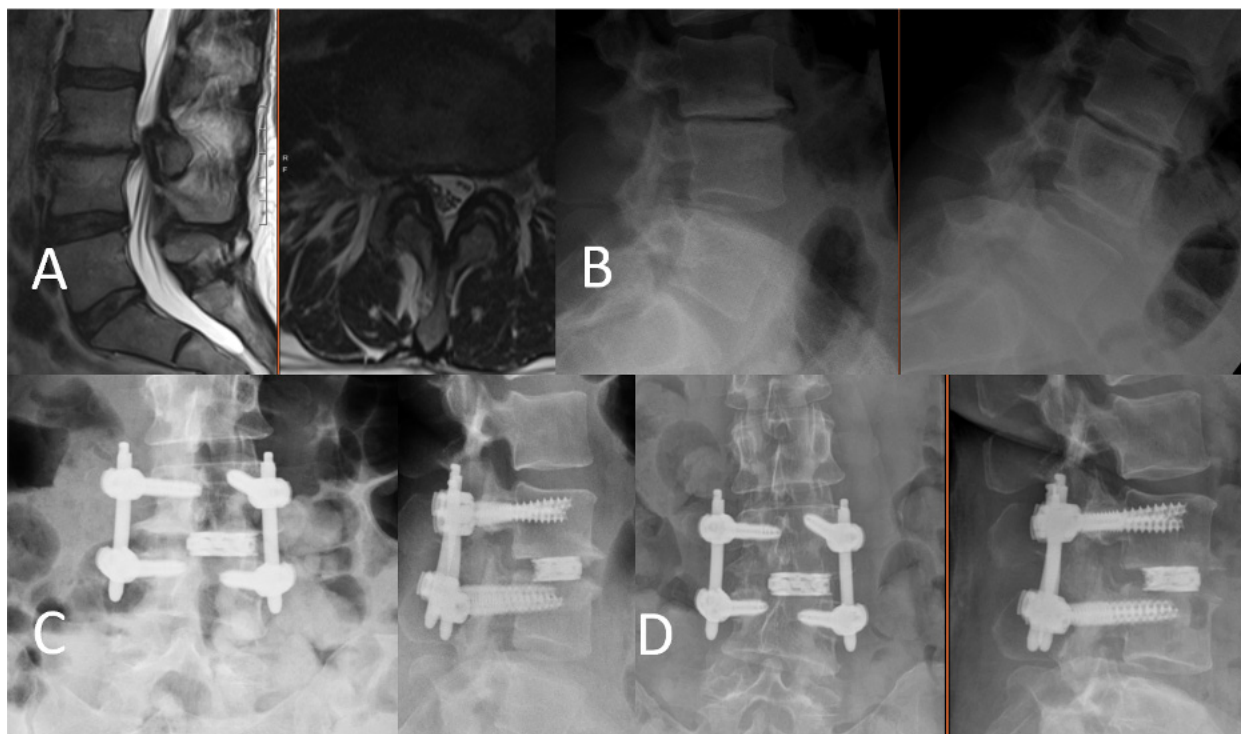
Radiographical evaluation of the patient. (A) Preoperative lumbar sagittal and axial magnetic resonance imaging without contrast showing degenerative disc disease, height loss, and disc bulge at L3-4 with left neuroforaminal stenosis. (B) Preoperative flexion-extension lumbar x-rays showing a grade 1 spondylolisthesis at L3-4. (C) Anterior-posterior and lateral lumbar x-rays immediately after L3-4 percutaneous lumbar interbody fusion (perCLIF) showing satisfactory placement of the interbody expandable cage and rigid pedicle screw and rod fixation. (D) Anterior-posterior and lateral lumbar x-rays 6 months after L3-4 perCLIF showing appropriate hardware placement.
